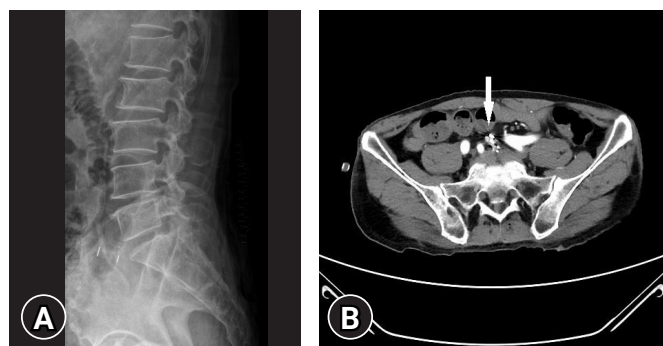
(A) Lateral lumbar X-ray image showing anterior migration of fusion cage. (B) Axial image of abdominal computed tomography angiography showing fusion cage just below iliac artery bifurcation (white arrow).
